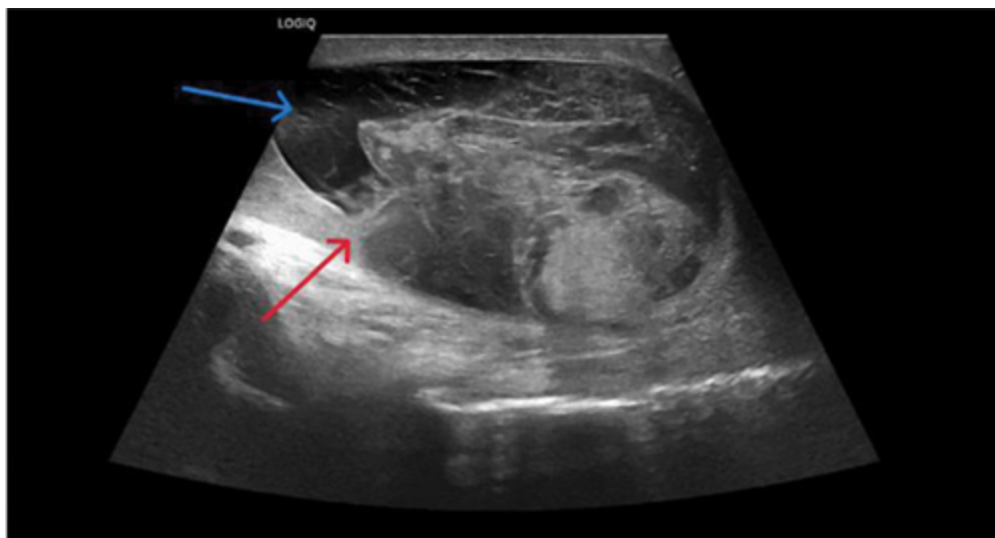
Ultrasound imaging showing testicular albuginea disruption (red arrow) and haematoma (blue arrow) consistent with testicular rupture. *Source:* Adapted from Eldore LW, Borries T, Malick H, Mason K, DePrisco G. Testicular Rupture Following Motorcycle Accident. *Cureus*. 2023 Jul 9;15(7):e41609. doi:
